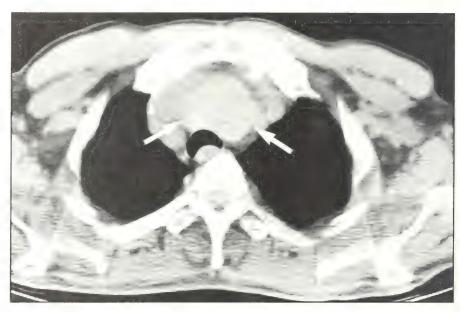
Non-contrasted CT of the thorax shows a mass anterior to the trachea. The mass contains areas of high and low density and is continuous with the cervical thyroid (arrows).
